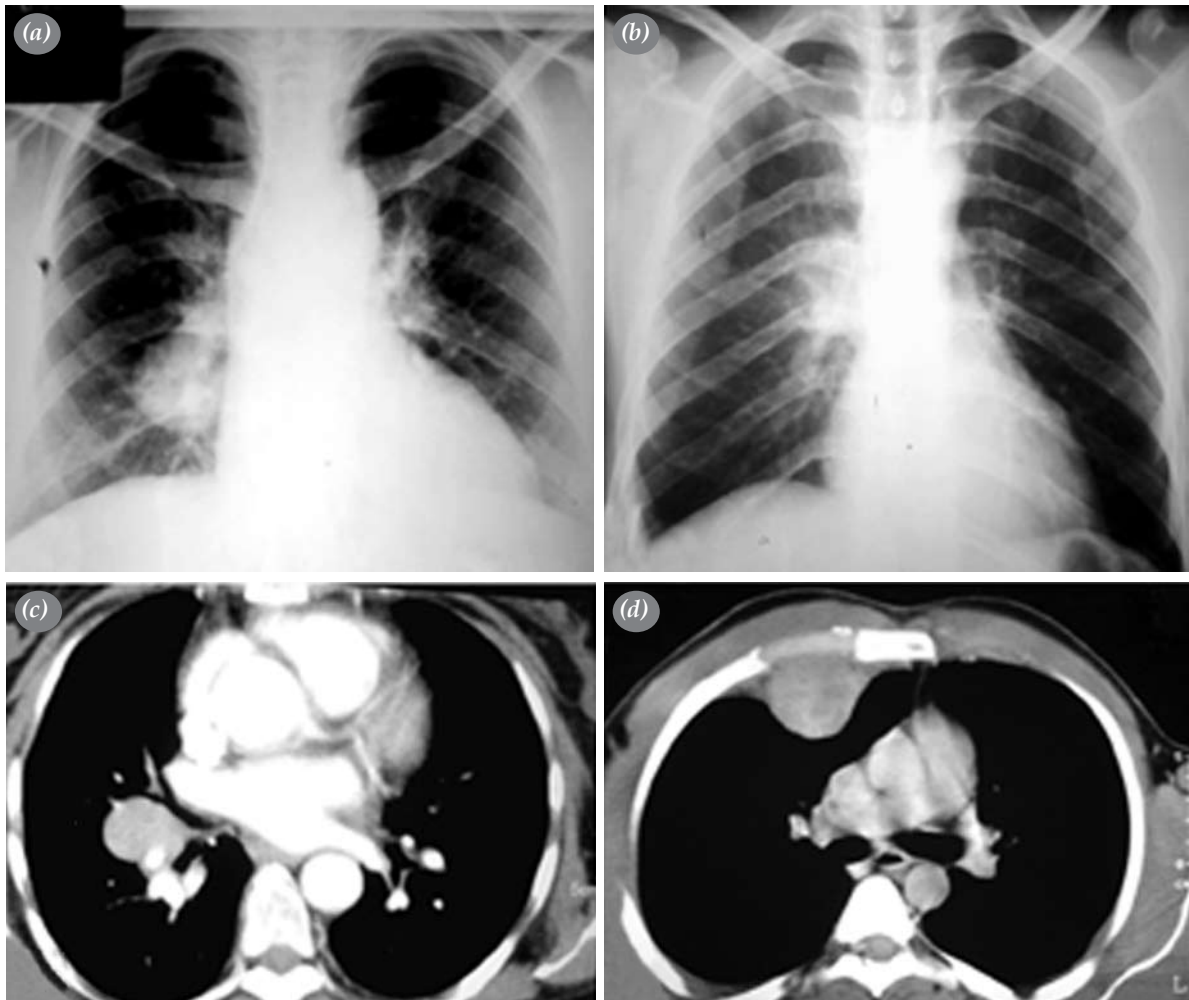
(a, b) Chest X-rays showed hilar density and (c) Thorax computed tomographies revealed a well-circumscribed, solid mass lesion in pulmonary parenchyma and (d) the chest wall.
